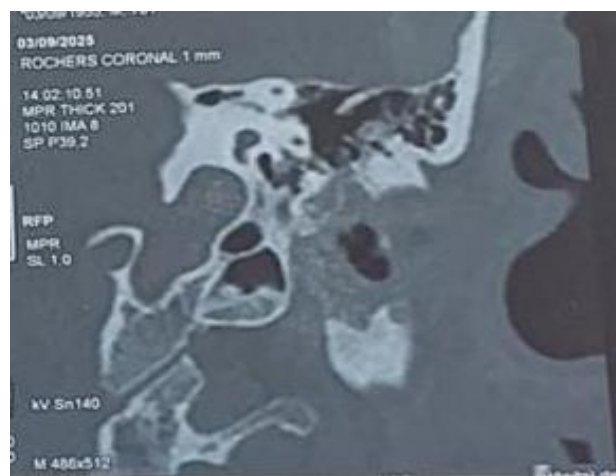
Coronal temporal-bone CT of the left ear, showing posterior extension of the cholesteatoma involving the whole mastoid, with lysis of the mastoid cortex. (stage III)
